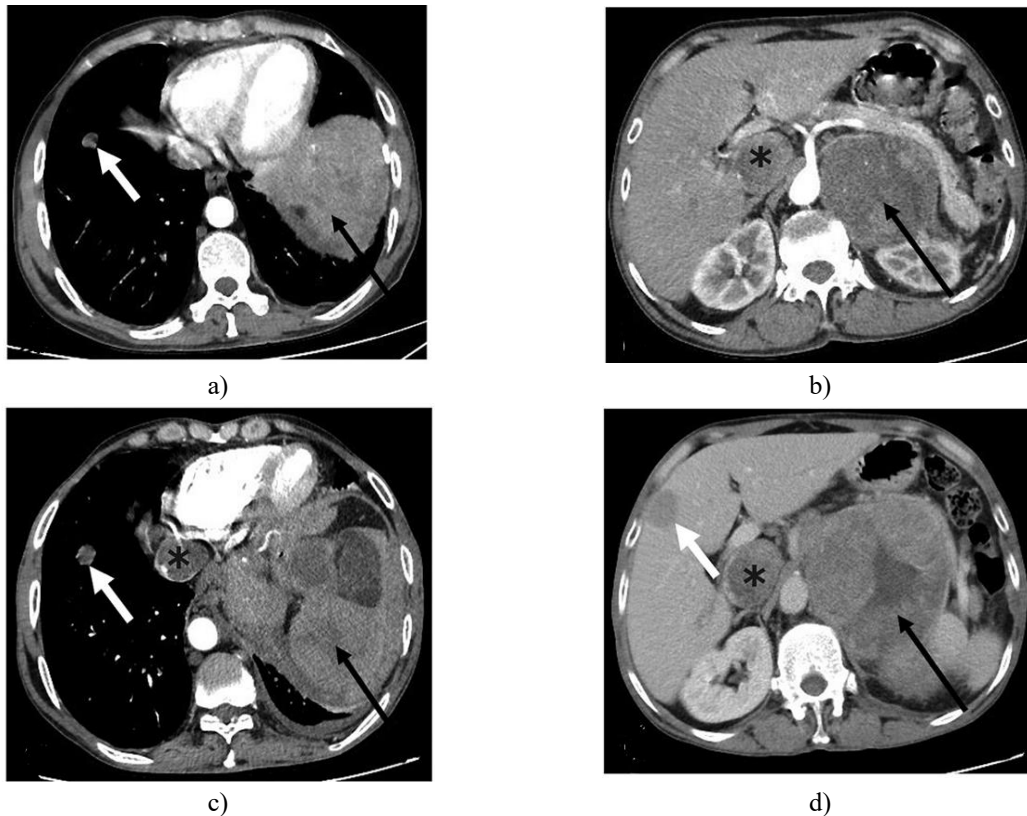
CECT images: (a–d): CECT of the abdomen shows an irregular soft tissue mass in the left sub-diaphragmatic area (a, c: black arrows) and retroperitoneum (b, d: black arrows) with multiple tumor thrombus formations in the IVC (b, c, d: asterisks) and multiple metastases in the lungs (a, c: white arrows) and liver (d: white arrows). A and B are 3 months before the comparison, and C and D are 3 months after it. Intrahepatic metastases were newly added, and other masses were significantly enlarged. Abbreviations: CECT = contrast-enhanced computed tomography; IVC = inferior vena cava.
